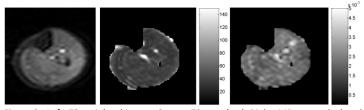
Left: T2-weighted image. Center: T2 map (ms). Right: MD map calculated from the MEMS acquisition (mm^2/s)
